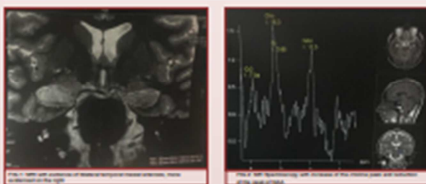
Mesial temporal sclerosis with FLAIR-weighted sequence.
